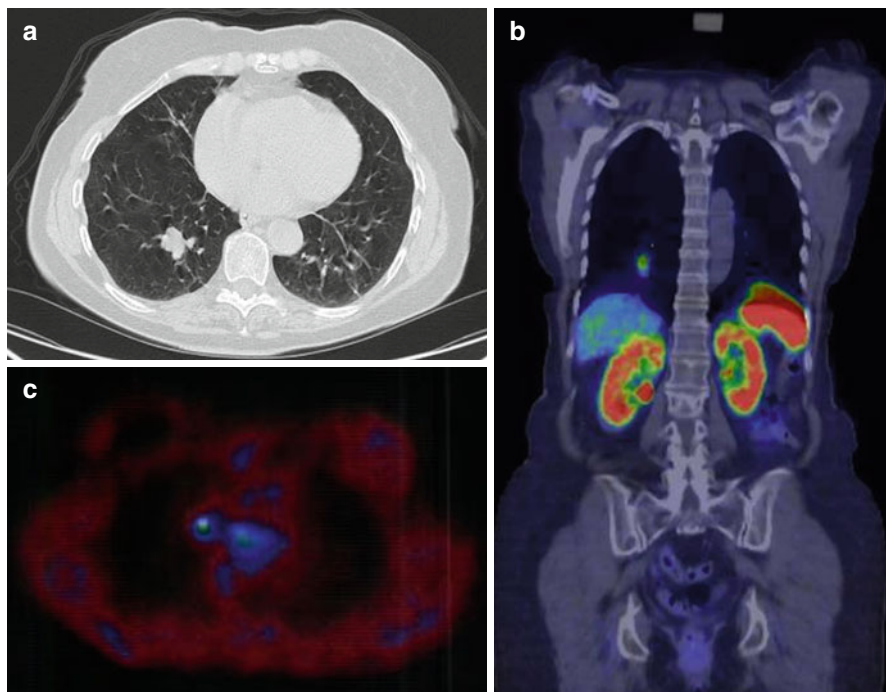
(a) CT scan showing a carcinoid in the right lung. (b) PET with ^{68}Ga -DOTATATE showing a carcinoid in the right lung. (c) PET with ^{11}C -5-HTP showing a right hilar lymph node metastasis from a typical carcinoid in the right lung, 9 years after primary surgery
